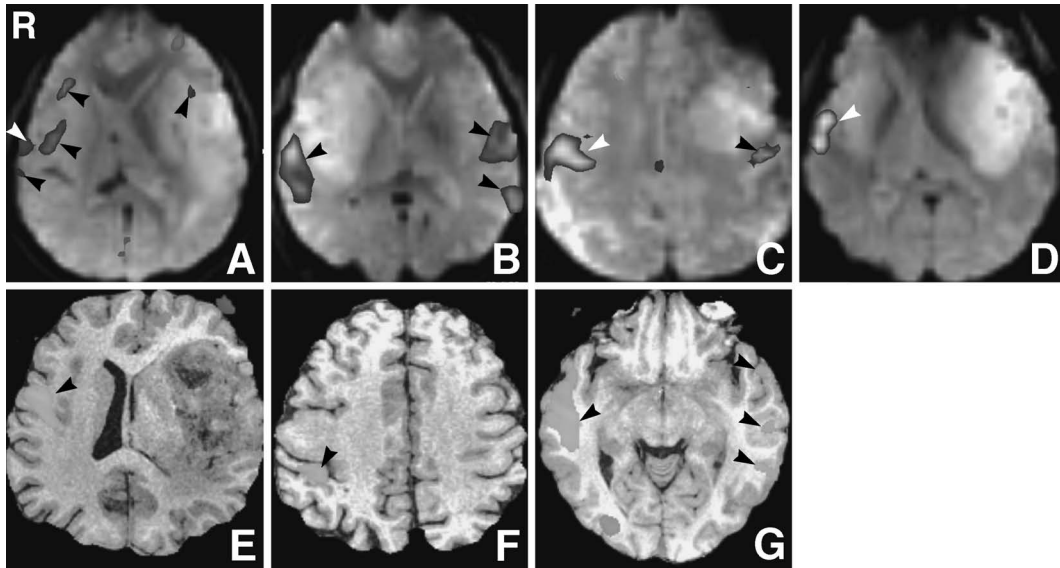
Preoperative functional magnetic resonance images of each case with suspected functional reorganization. With the language task, interhemispheric language reorganizations were suspected in all patients except Case 24, as blood oxygen level-dependent (BOLD) activities (arrowheads) presented in nondominant mirror regions to classical anatomical speech centers in dominant hemispheres. In Case 24 with the finger tapping task, the BOLD activity presented in the post-central gyrus, or sensory cortex in normal anatomy (suspected motor function reorganization). Right hemisphere is dominant in Case 14. A: Case 10, B: Case 14, C: Case 15, D: Case 16, E: Case 22, F: Case 24, G: Case 25.
